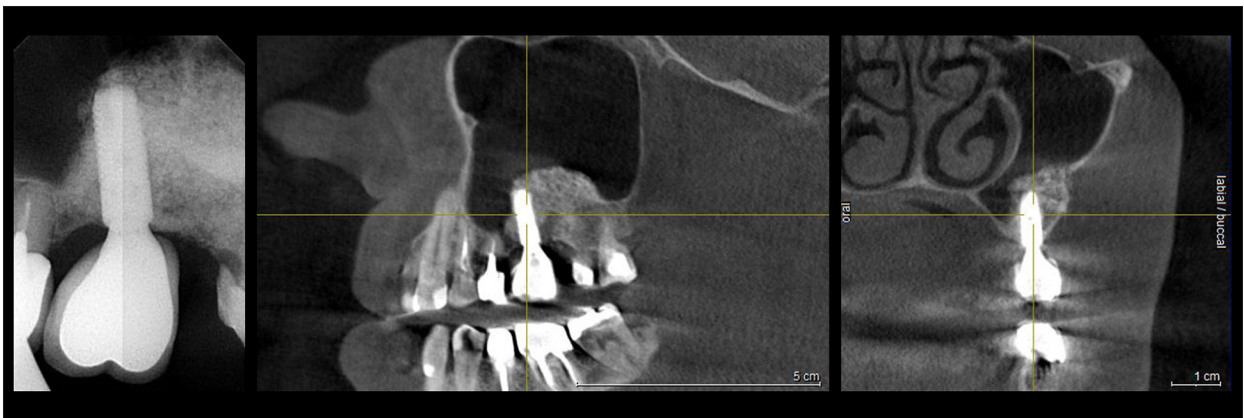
RVG, CBCT: OsseoSpeed™ regular implant. T2, 36 months.
